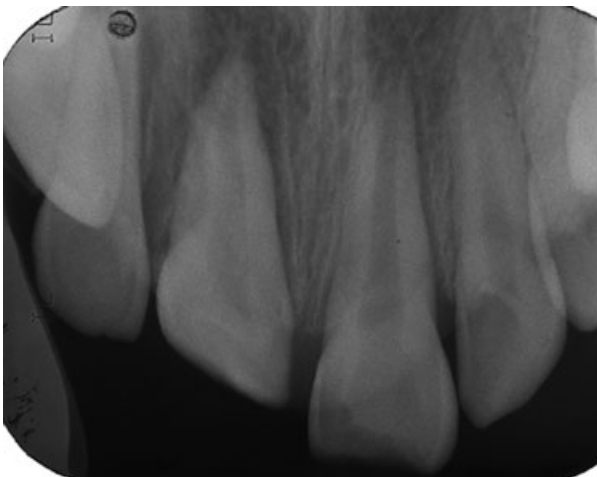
Preoperative radiographic view.
